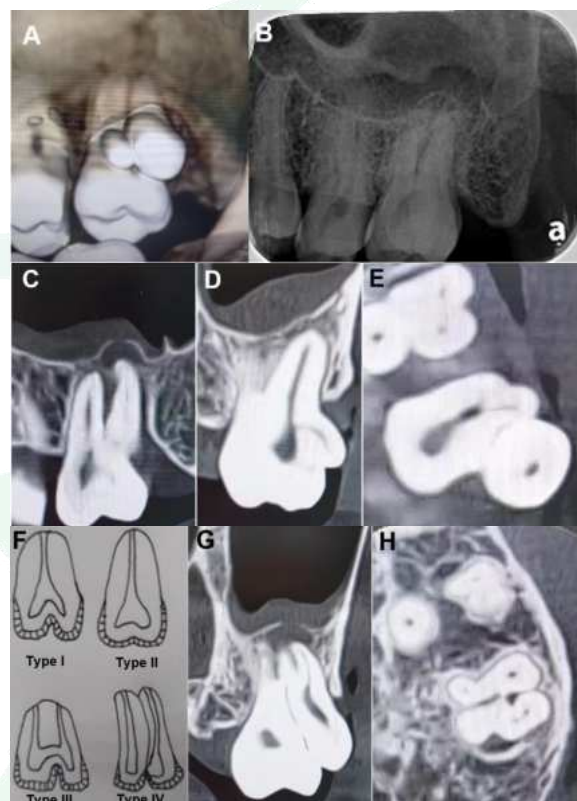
(A) 3D reconstructed image of atypical crown morphology. (B) Periapical radiograph. (C) Sagittal view, a periradicular radiolucency involving the fused root—comprising the D root of the UL7 and the root of the extra disto-buccal crown—extended into the sinus, causing membrane thickening. (D) Coronal view, isolated chamber in extra buccal crown. (E) Axial view, trifid crown. (F) Types of double teeth (Redrawn from Sperduti *et al.* 2021). (G) Coronal view, canal morphology of the extra disto-buccal crown. (H) Axial view, Canal morphology of the fused complex in the apical third.
